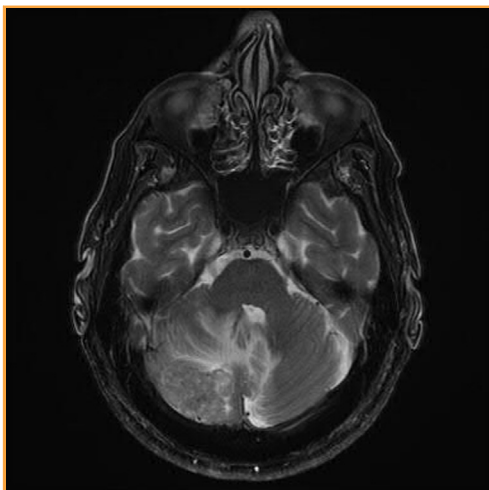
Contrast-enhanced T2-weighted magnetic resonance image showing symptomatic cerebellar metastasis with associated cerebellar edema and distortion of the fourth ventricle in a patient with esophageal adenocarcinoma.
